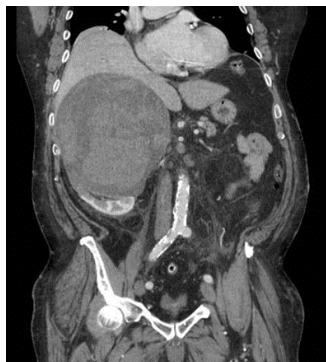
Follow up CT 3 weeks later revealed an enlarging mass with heterogeneously increased density consistent with acute internal hemorrhage.
